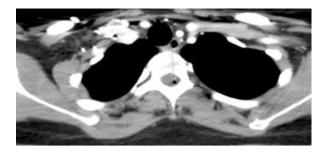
Computed tomography scan with contrast of the thoracic spine revealing a small focus of epidural air is seen at thoracic 3 level
